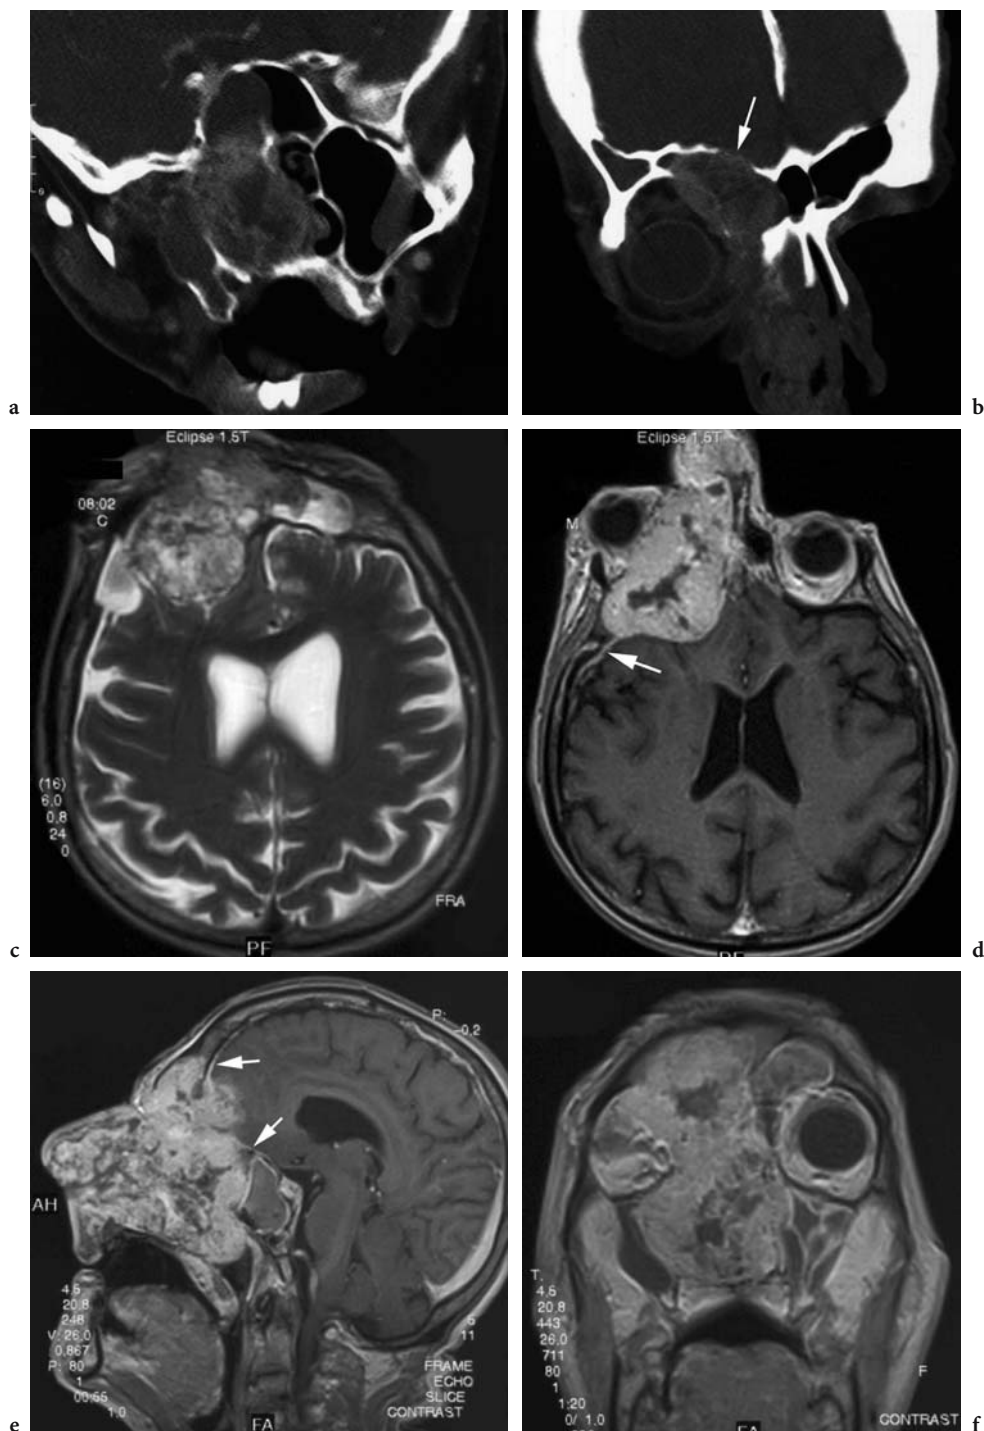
Nasal and paranasal sinus metastases in a 69-year-man concomitant to renal cell carcinoma of the left kidney. a Coronal oblique CT scan shows a large soft tissue mass occupying the right maxillary sinus, the right ethmoid cells, the sphenoidal sinus, and the lateral wall of the right nasal cavity, with extensive destruction of nasosinusal (bone) septum. b Coronal oblique CT scan anterior to a shows an extension of the tumoral mass into the right orbit and the frontal sinus with intracranial extension (*arrow*) through bony destruction of the upper wall of the frontal sinus. c Axial T2-weighted MR image shows the heterogeneous hyperintense mass, strongly enhancing after d contrast administration on axial T1-weighted image. There is central tumoral necrosis and marked right-eye proptosis. A dural tail enhancement (*arrow*) is also observed, probably due to meningeal involvement. e Sagittal and f coronal contrast-enhanced T1-weighted MR images demonstrate the extensive involvement of the nose and paranasal sinuses and confirms the meningeal involvement (*arrows*) as well. (Image courtesy of M. SZYMANSKI)
